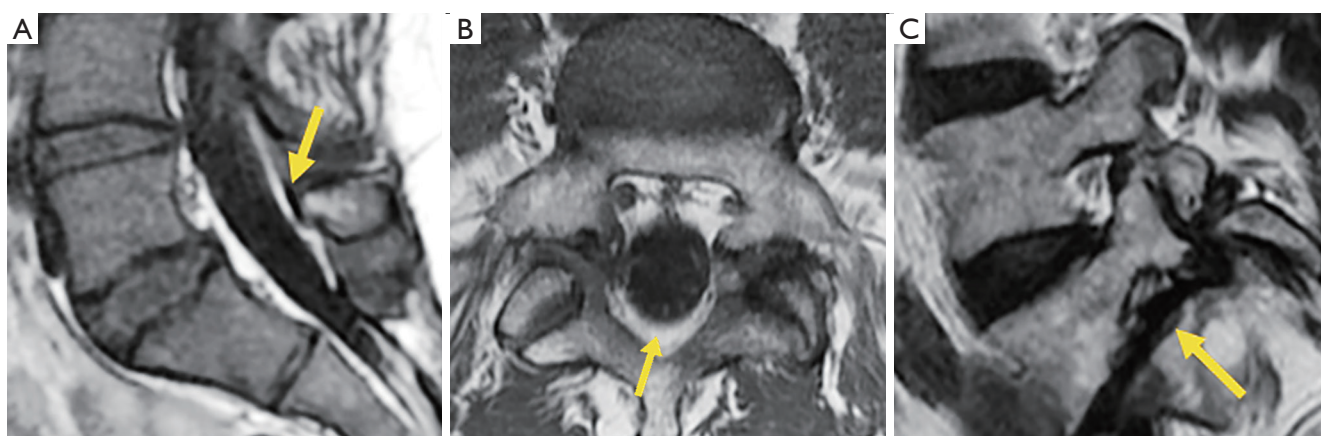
MRI Indirect signs of spondylolysis and spondylolisthesis. (A) Epidural fat interposition between the thecal sac and the L5 spinous process in spondylolysis without spondylolisthesis. (B) Widening of the central canal (arrow) and foraminal stenosis (arrow) (C) in spondylolysis with spondylolisthesis. MRI, magnetic resonance imaging.
